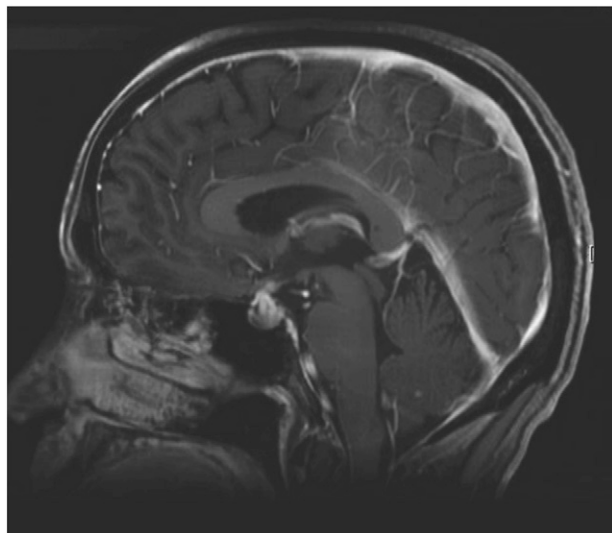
Brain magnetic resonance image of a patient with CTLA4 mAb-induced hypophysitis. Sagittal T1-weighted postcontrast image showing an enlarged and intensely enhancing pituitary gland as well as thickening of the stalk affecting the optic chiasm.
